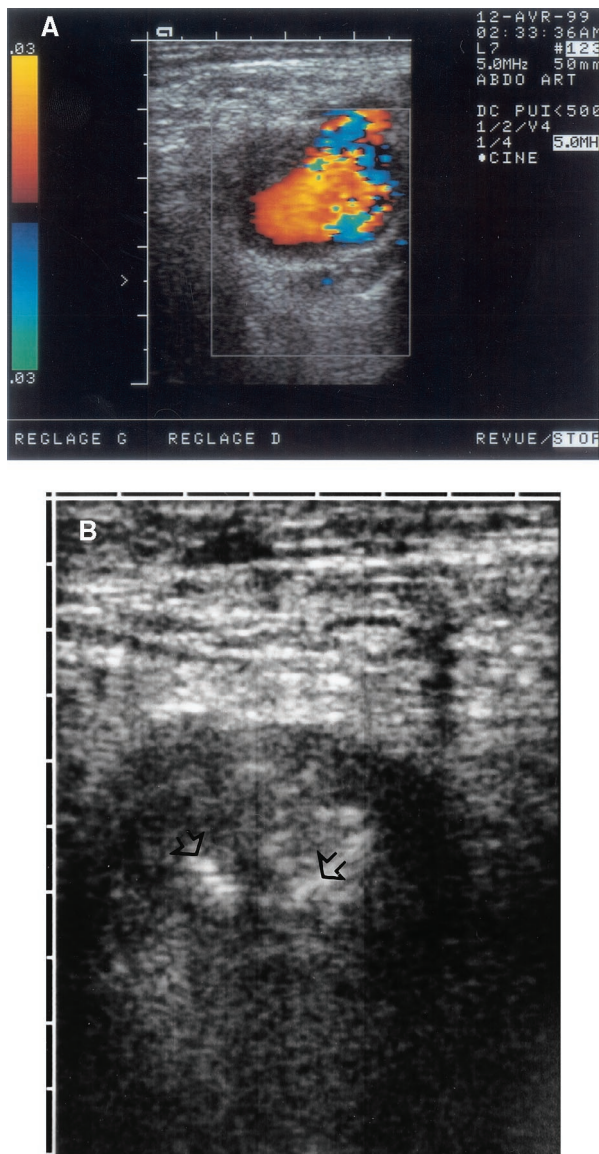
Duplex ultrasound scan of pseudoaneurysm located at femoral bifurcation before (A) and after (B) coil embolization. Coils appear as hyperechoic images within lumen of PCFP (arrows).
